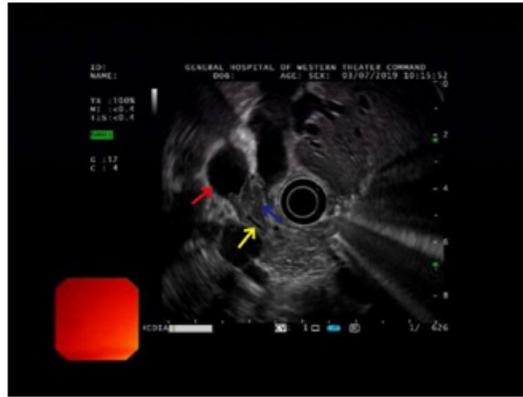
Endoscopic ultrasonography (EUS) revealed dilatation of the common hepatic duct (red arrow), an occupying lesion (blue arrow) and stenosis of the common bile duct (yellow arrow).
